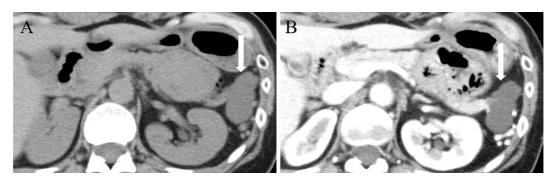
A Japanese woman in her 50s underwent abdominal ultrasonography during a medical checkup, which revealed enlargement of a pancreatic tail cyst from 25 mm to 36 mm over 1 year. (A) One year ago, (B) this time (arrow).
